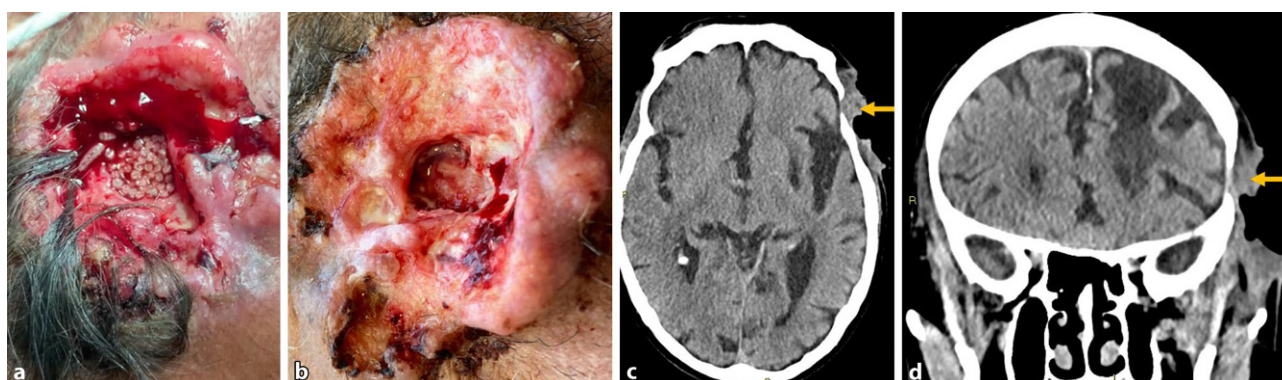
a Maggots inside an ulcerated wound in the frontoparietal area; b 1 week after mechanical removal of fly larvae and debridement; c, d computed tomography showing bone
